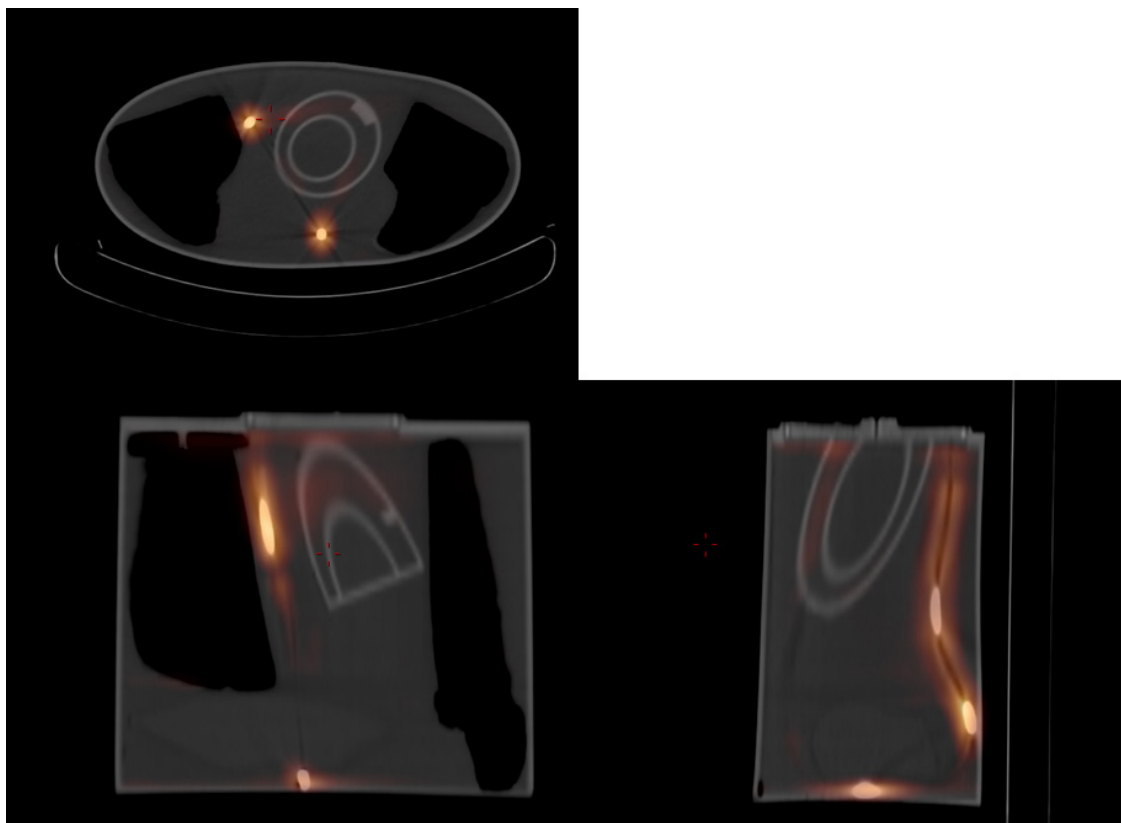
Difference image between reconstructions of acquisitions performed with and without contrast. Only if a difference image is calculated is it clear that the contrast material introduces an increase in reconstructed SPECT counts through the attenuation correction. In this case about 5–10% of maximum. Images reconstructed with attenuation maps based on 140 kV CT.
